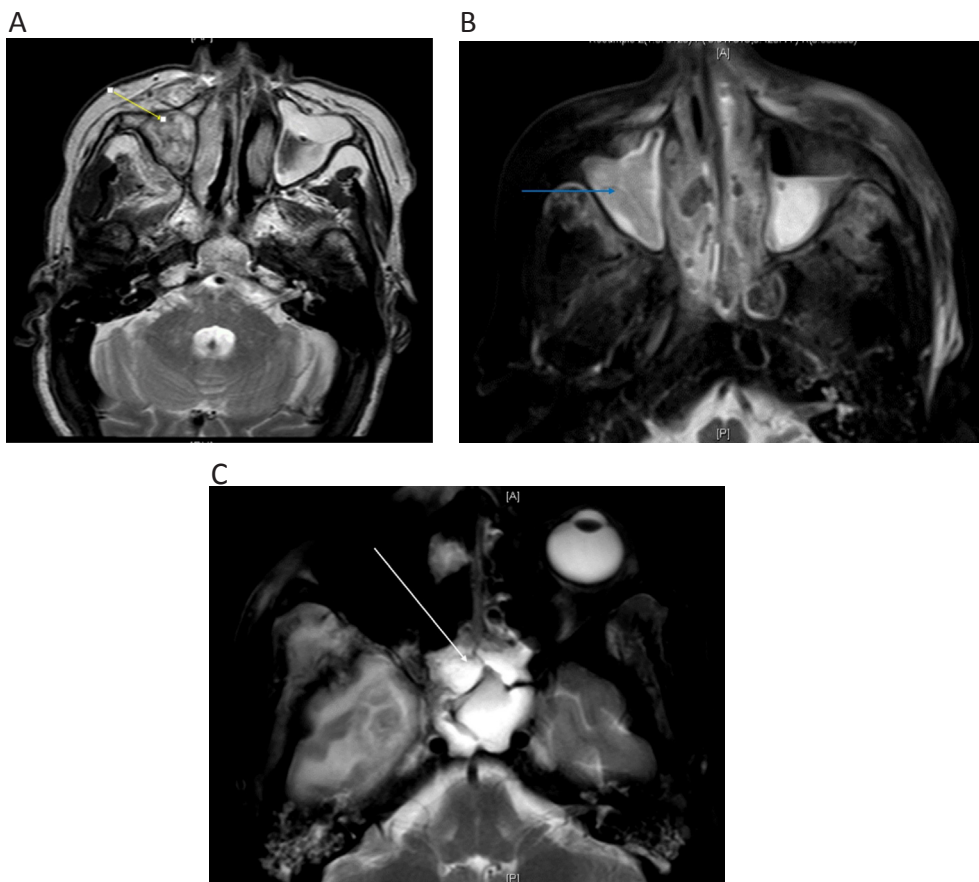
T2 patterns in mucormycosis. T2 MRI showing A. Heterogeneous pattern involving the maxillary sinus (yellow arrow). B. Isointense pattern involving the maxillary sinus (blue arrow). C. Hyperintense pattern involving the sphenoid sinus (white arrow).
